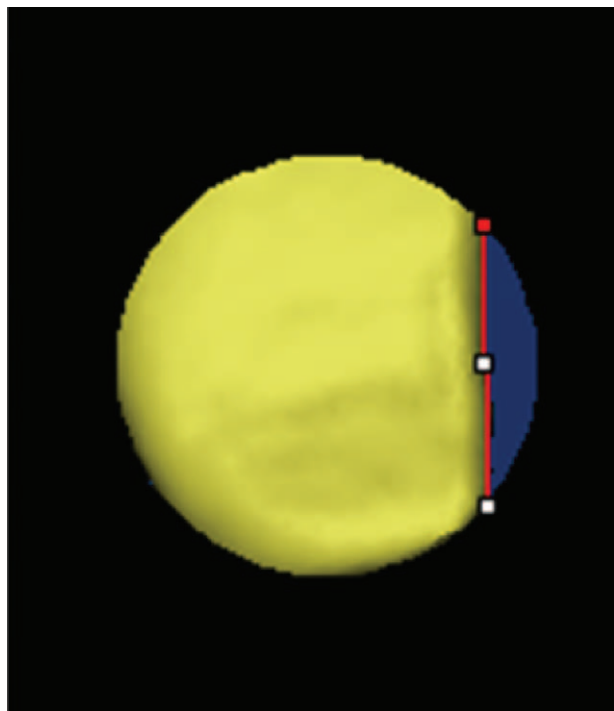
3-D computed tomography image of the scapula showing the en-face view.
